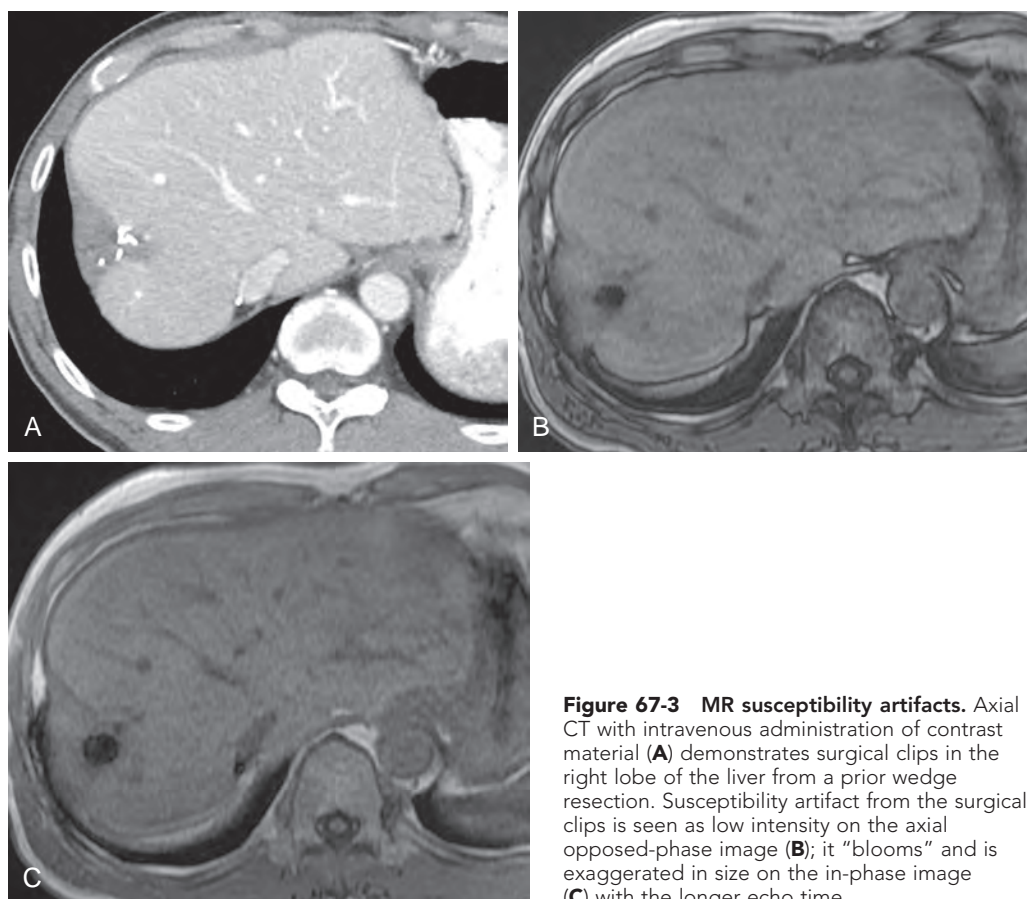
MR susceptibility artifacts. Axial CT with intravenous administration of contrast material (A) demonstrates surgical clips in the right lobe of the liver from a prior wedge resection. Susceptibility artifact from the surgical clips is seen as low intensity on the axial opposed-phase image (B); it "blooms" and is exaggerated in size on the in-phase image (C) with the longer echo time.
